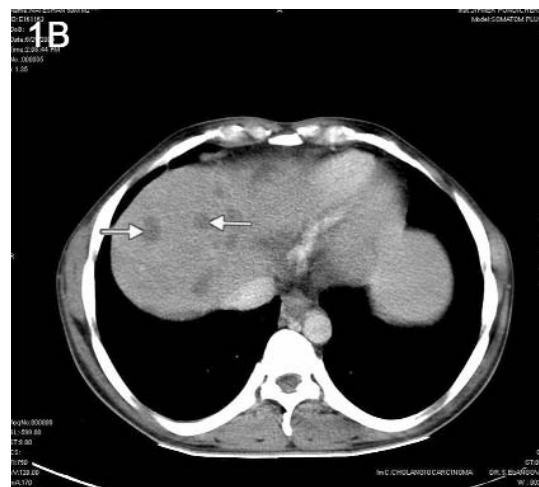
CT film showing multiple focal lesions in the liver (arrow)
